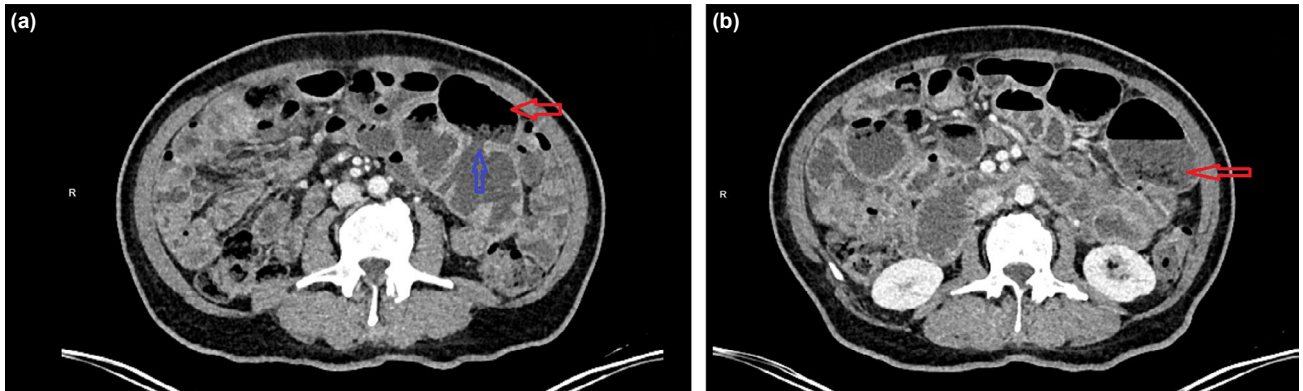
Axial plane CT images of the abdomen obtained without oral contrast agent administration after intravenous contrast agent administration. (a) A wide wall discontinuity (blue arrow) in the jejunum and a large diverticula (red arrow) extending from this area. (b) A large diverticula (red arrow) in the jejunum.
